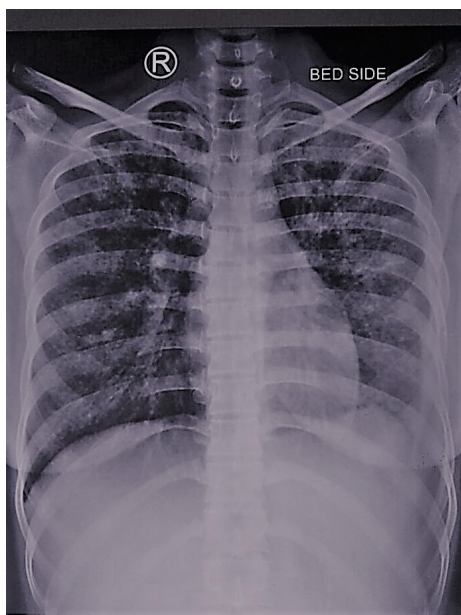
Chest X-ray shows bilateral infiltrates predominantly in upper zones
